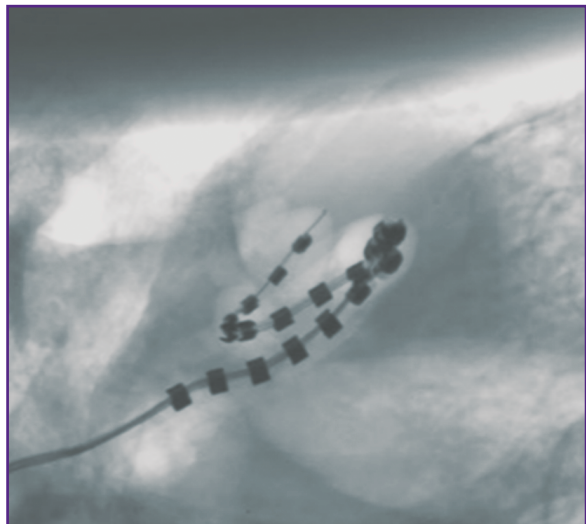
Temporal bone radiograph obtained by microfocus tomography technique
